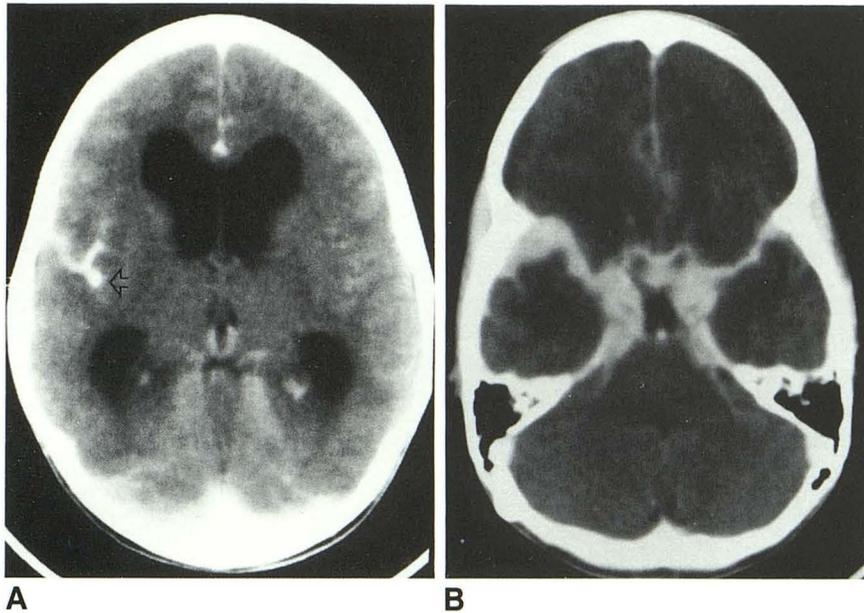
A, Enhanced axial CT; PNET meninges (case 21). Hydrocephalus and meningeal enhancement in the right sylvian fissure (*open arrow*). No intraaxial tumor was seen on this or on any subsequent scan.
